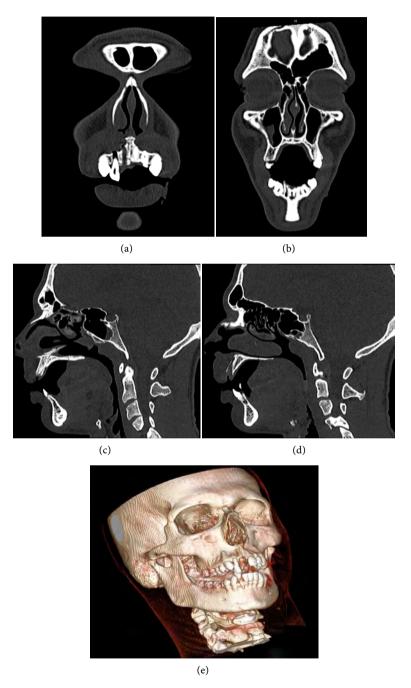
Selected coronal (a) and (b), sagittal (c) and (d) and three-dimensional reconstruction (e) of a maxillofacial CT scan demonstrating traumatic extraction of the right upper central incisor and subluxation of the upper and lower right lateral incisors with an associated fracture through the alveolar ridge of the maxilla and mandible.
